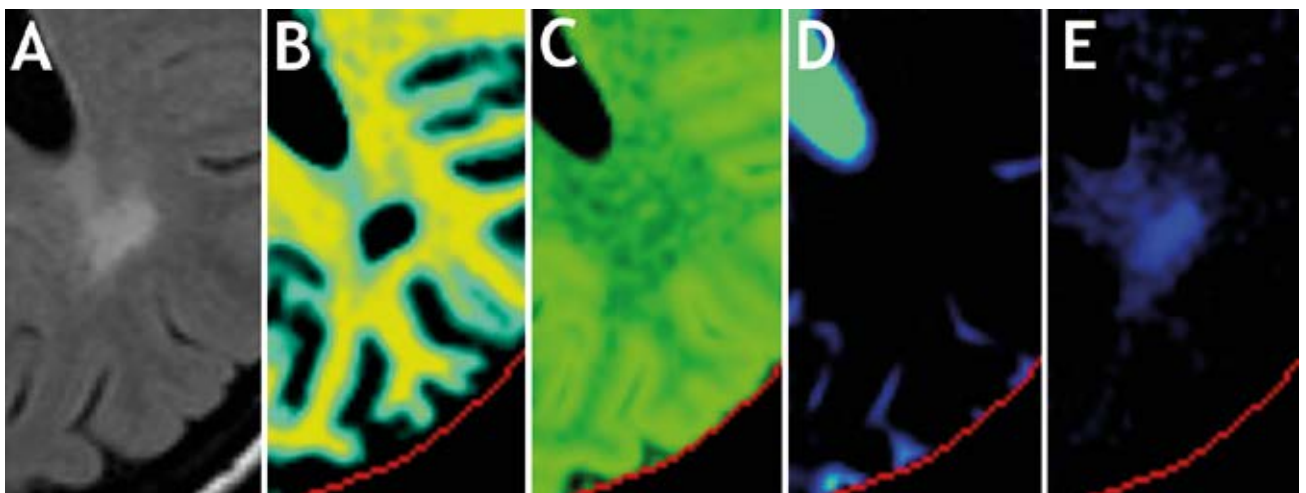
Example of synthetic MRI on an MS patient, showing new kinds of brain segmentation. Only a zoomed part of an axial slice is shown. Based on a single acquisition, different conventional images can be recreated such as a T1W, T2W or FLAIR (A). Using the same data, tissue can be assessed, in this case on the presence of myelin (B), cells (C), cerebrospinal fluid (D) and edema (E). Automatic tissue segmentation enables more objective patient monitoring since these values can be monitored over time and compared to a healthy reference.
